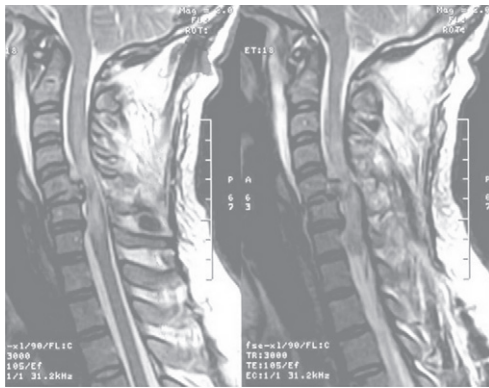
MRI T 2 WI showing cord edema less than 3 segments
